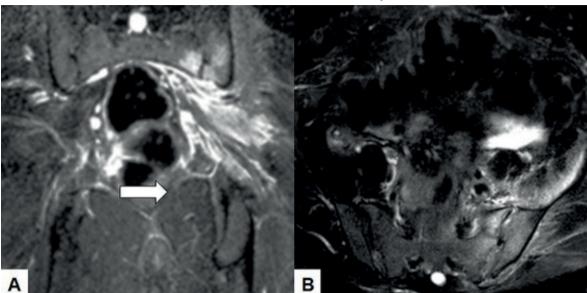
CORONAL MAGNETIC RESONANCE IMAGE AFTER TREATMENT OF THE LEFT SACROILIAC JOINT. THE ARROW SHOWS DISAPPEARANCE OF THE COLLECTION WITH SLIGHT RESIDUAL PERSISTENT SOFT TISSUE CHANGES AND DECREASED BONE MARROW EDEMA OF THE JOINT.
